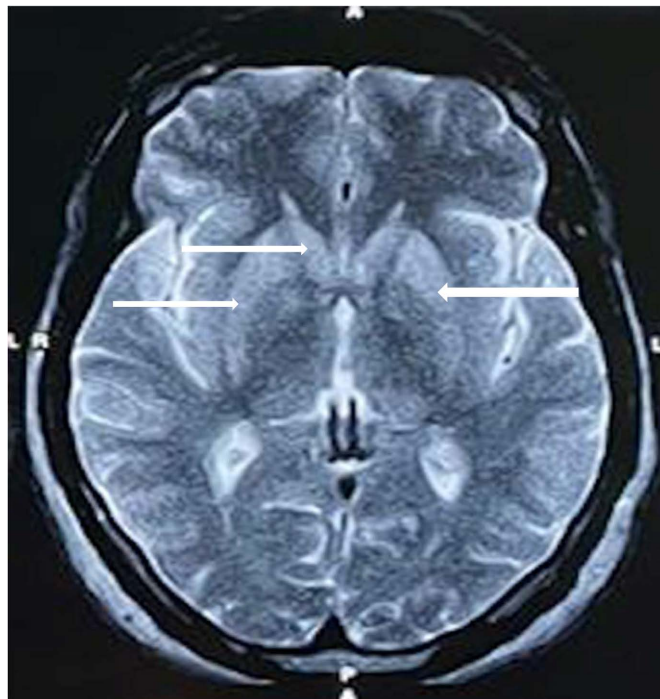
Bilateral and symmetrical hyperintensity in caudate and lenticular nuclei in T2 sequence MRI (white arrows).
